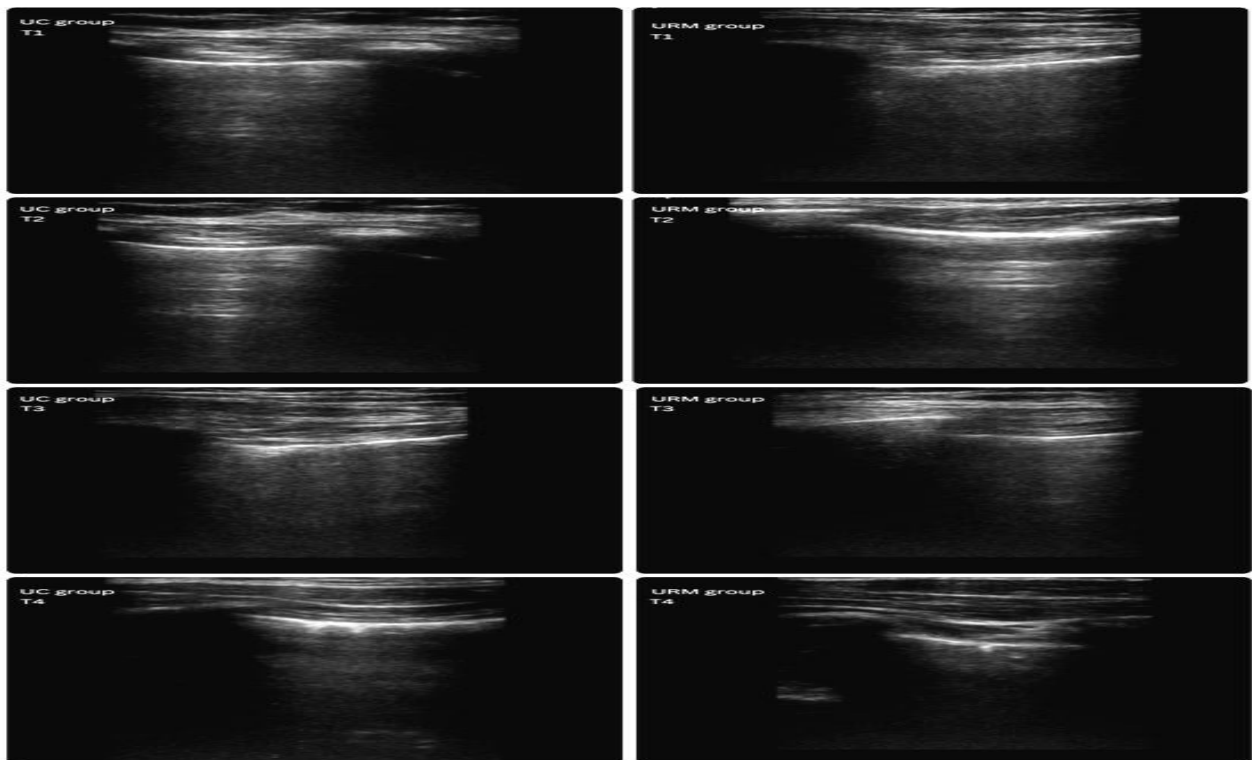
One patient's lateral chest wall lung ultrasound pictures taken at various time Zones-. T1: immediately before induction; T2: before extubation; T3: 15 min followed tracheal extubation; T4: 30 min after tracheal extubation; UC group: control group; URM group: ultrasound-guided recruitment manoeuvres group
